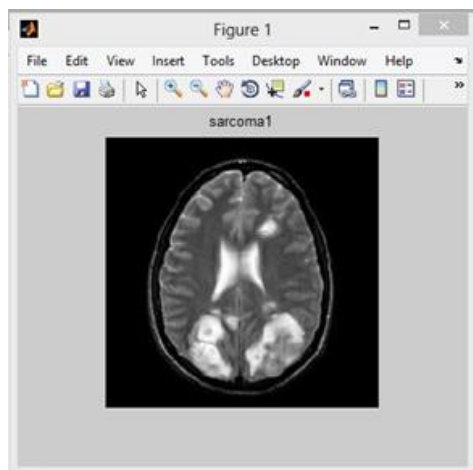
Original MRI image
